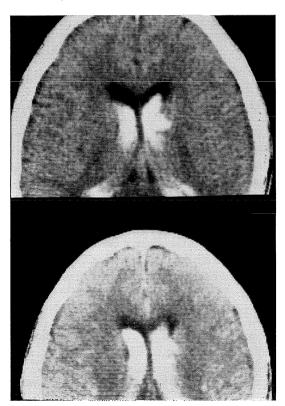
CT scans on admission. Plain CT (upper) and enhaced CT (lower).
